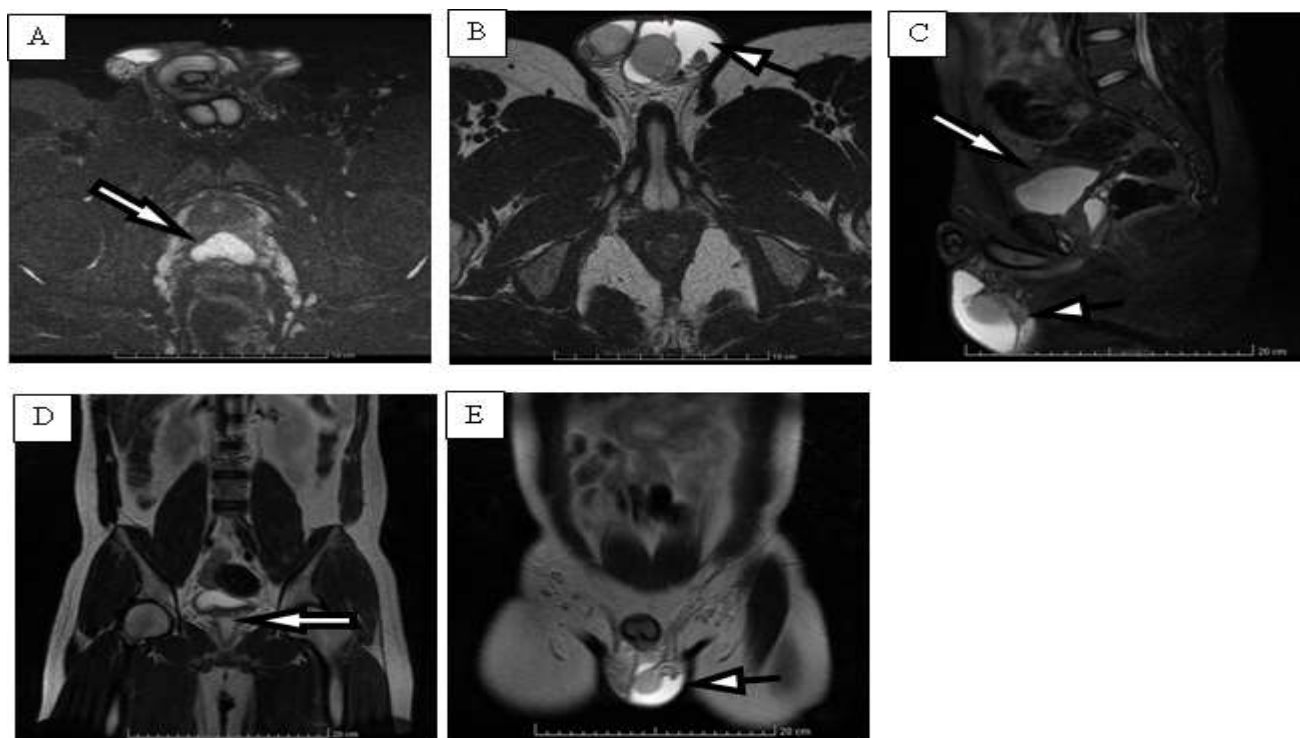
(Magnetic resonance imaging shows on the A-B.T2 Axial view, C.T2 Sagittal view, D-E.T2 Coronal view.
